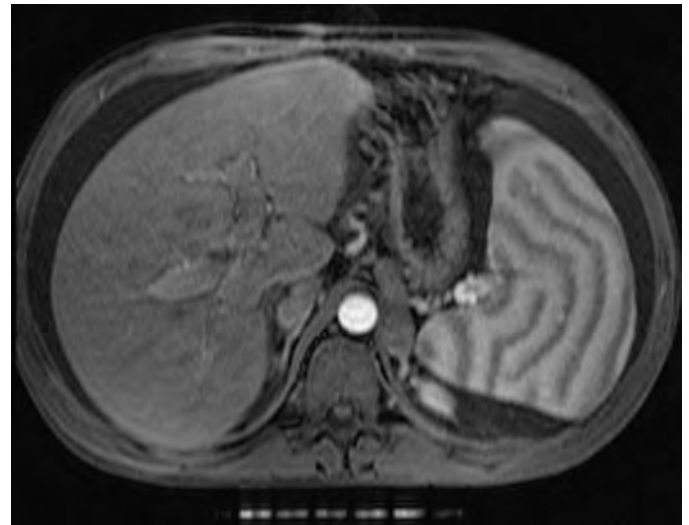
Splenic MR perfusion artifact. Axial view, volumetric interpolated breath-hold examination (VIBE) MR image obtained during administration of contrast material demonstrates transient splenic parenchymal perfusion patterns, including arcs and stripes.
